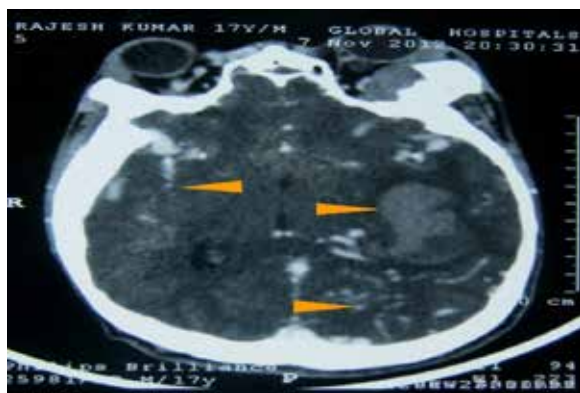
MRI brain showing bleed in left temporal lobe and A-V Malformations
